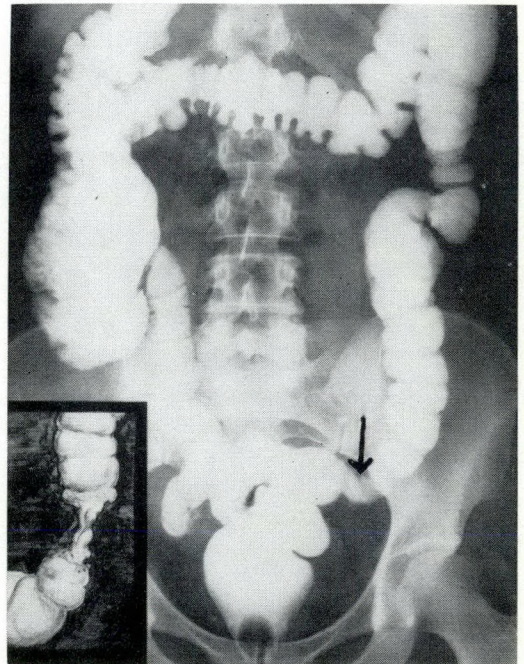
Case 1: The napkin-ring, constricting appearance of the lesion is portrayed in the corner insert. The large roentgenogram demonstrates a normal colon five years postoperatively; the arrow indicates the site of anastomosis.
